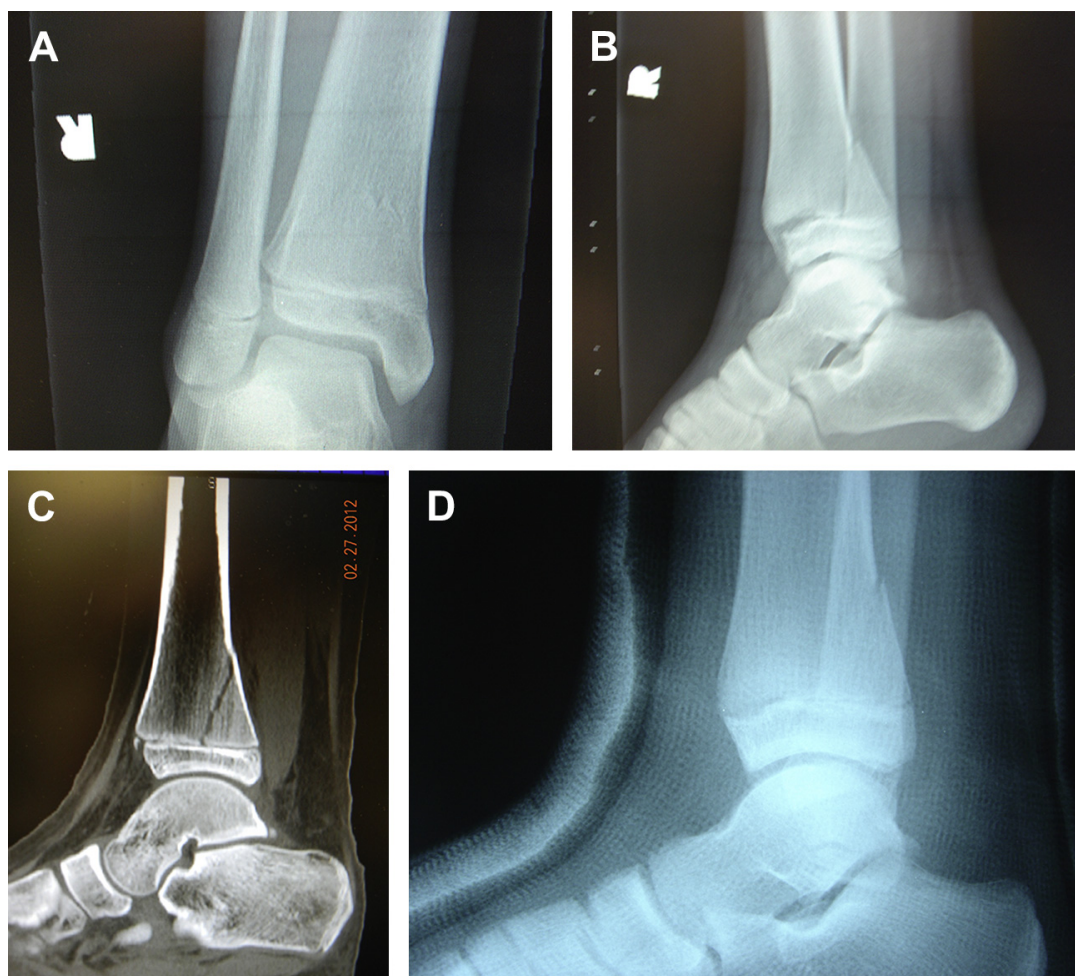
(A) Type 2 injury of the distal tibia. AP view shows subtle signs of metaphyseal fracture. The slip of the physis is not visible on the AP view. These fractures are most common in the adolescent years. (B) Lateral view clearly showing the slip through the physis with displacement. (C) CT scan clarifies the fracture pattern and extent. Advanced imaging is recommended for most articular injuries and can aid in decision making for treatment. (D) Recommended treatment is closed reduction with casting. Thick periosteum in the pediatric patient aids in reduction and maintenance of fracture position with distraction and casting. Growth interruption is not common with this type of injury.
